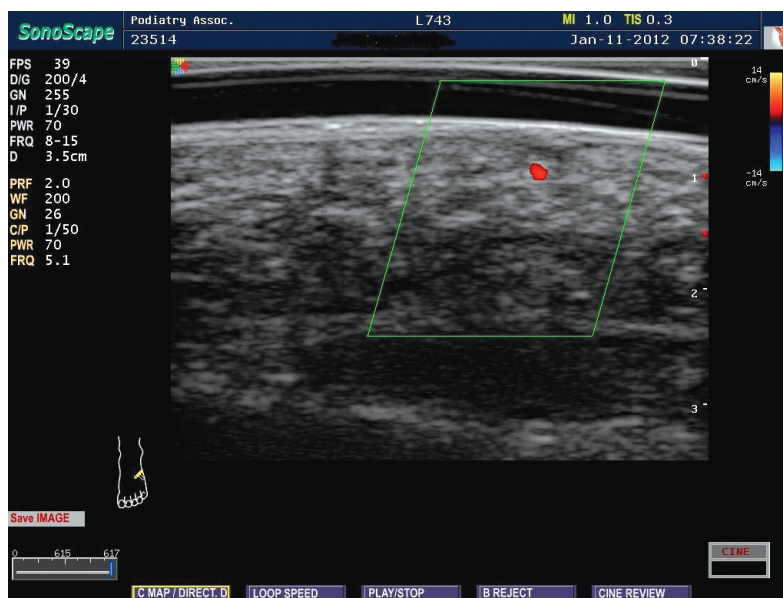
Triplex Power Doppler demonstrating capillary blood flow to verrucae with stand-off pad applied.
